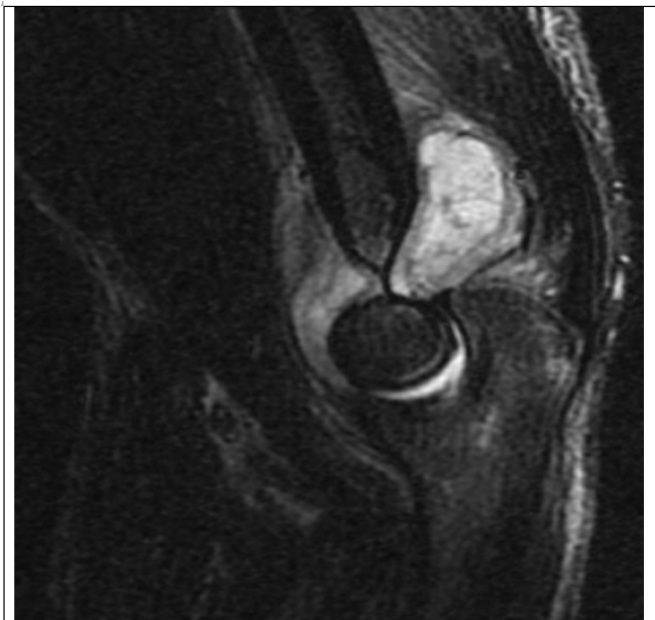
Sagittal T2-weighted magnetic resonance image demonstrating complex joint fluid within the olecranon and coronoid fossae, with surrounding soft tissue inflammation and joint capsule distention.
